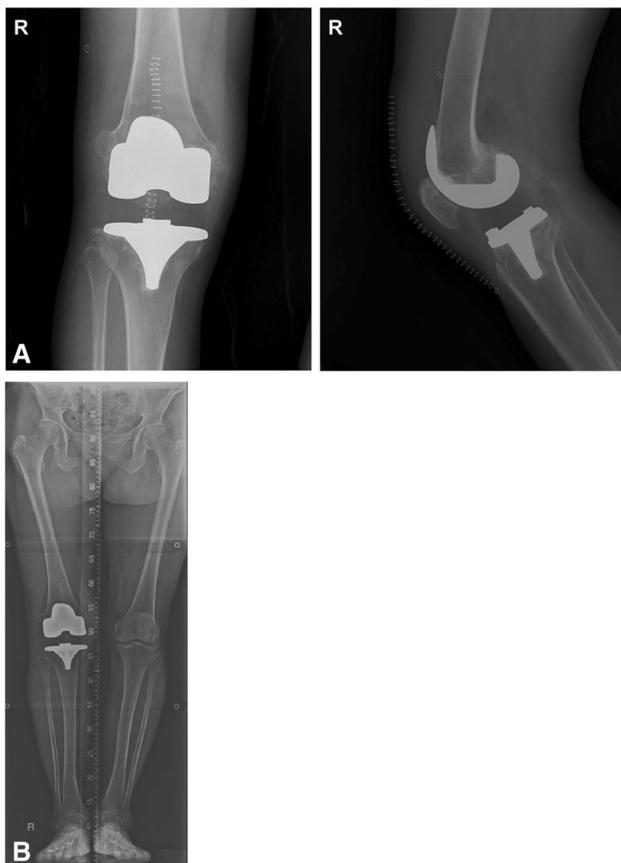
a Postoperative radiographs after revision surgery with reshaped constrained liner. b Postoperative scanogram with aligned right knee
